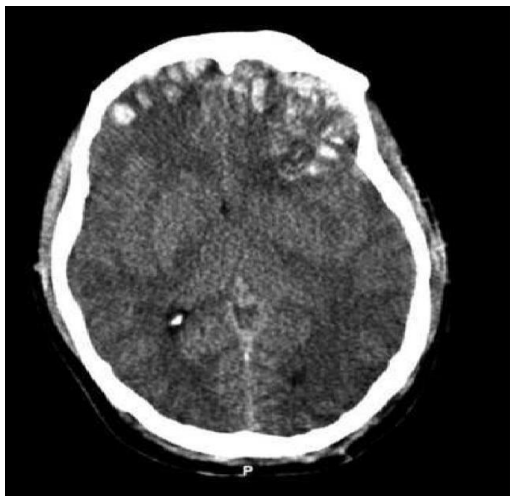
A CT scan of a patient suffering from brain injury. The caption for the photograph says, "Preoperative CT scan of the patient while he had a GCS of 14." According to the report's accompanying language, "emergent CT imaging revealed a sagittally oriented skull fracture extending from the vertex to the foramen magnum, as well as a transverse parietal and temporal bone fracture." Frontal, parietal, and temporal lobe contusions, interhemispheric bleeding, and a 1.7-mm-deep subdural hematoma on the left side were all present. After the basilar cisterns were removed, the midline construction remained unchanged.
